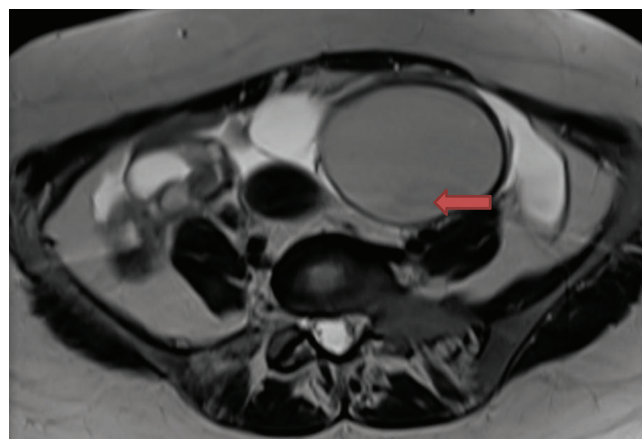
T2 weighted axial section of MRI of pelvis of a 36 year old reveals left ovarian endometriotic cyst with T2 shading. Mild free fluid is also seen in the pelvis.
